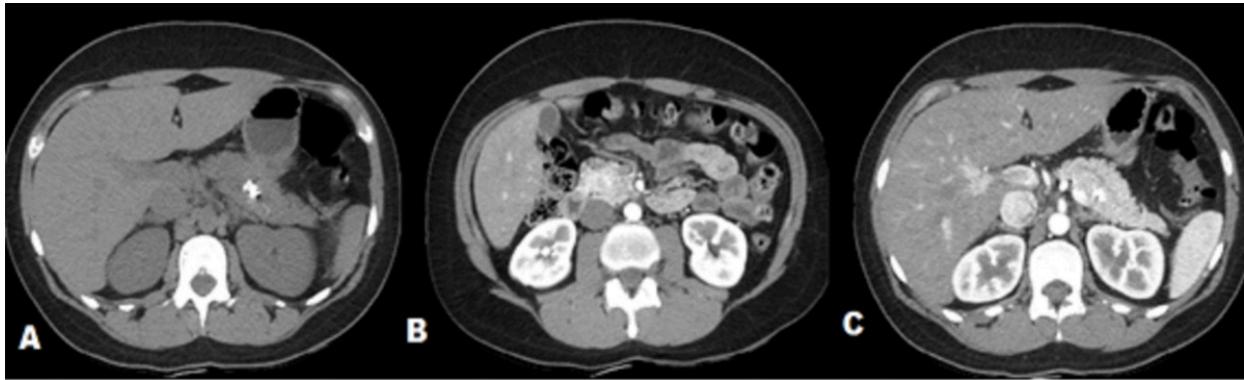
Axial CT images, with no contrast enhancement (A), and arterial (B and C) enhancement showed three nodular images, all with low attenuation, in the pancreas, one in the neck, and two in the cephalic portion. References: Radiology Department, São Carlos Imagem, São Carlos Hospital - Fortaleza/BR 2018
